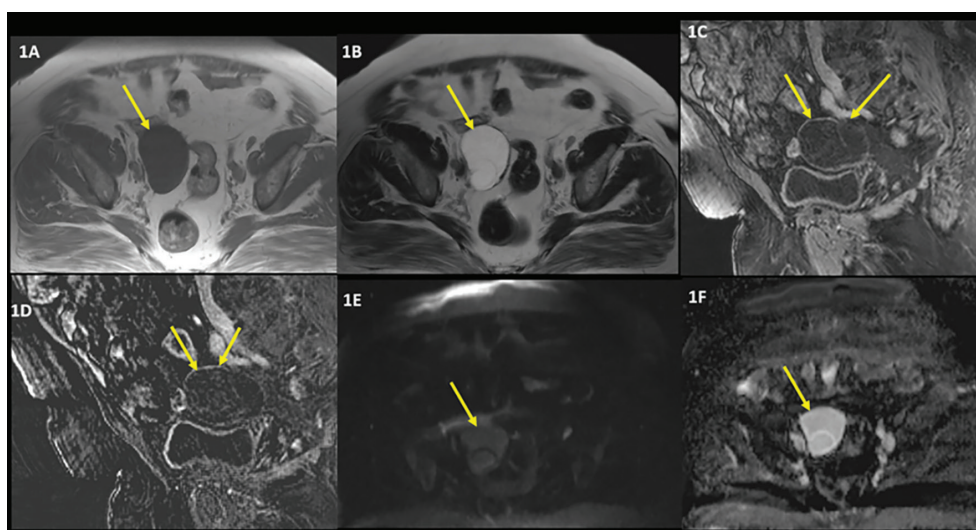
A 78-year-old woman with incidental ovarian mass. A 61x47x47 mm lesion was observed in the right ovary compared to the striated muscle; homogeneously hypointense in T1-weighted (Figure 1A arrow); homogeneously hyperintense in T2-weighted (Figure 1B arrow). In the postcontrast series, a trilobulated cystic lesion with slight contrast enhancement in its wall and septa (Figure 1C arrow and subtraction Figure 1D arrow) and increased diffusion on diffusion weighted imagings (Figures 1E and 1F arrows) was observed, biopsy proven serous cystadenoma
